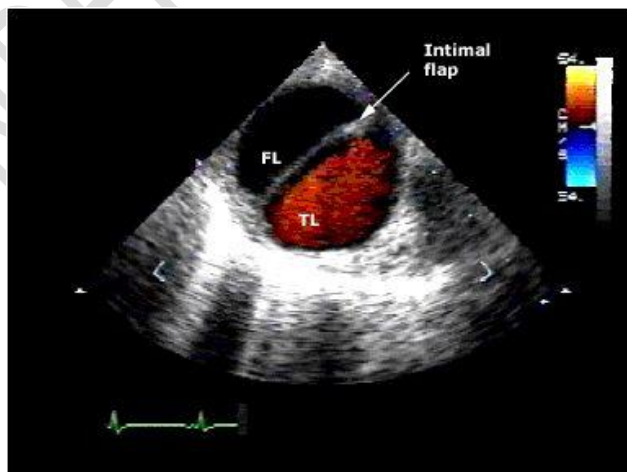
Transesophageal Echocardiography of Aortic Dissection (12)
